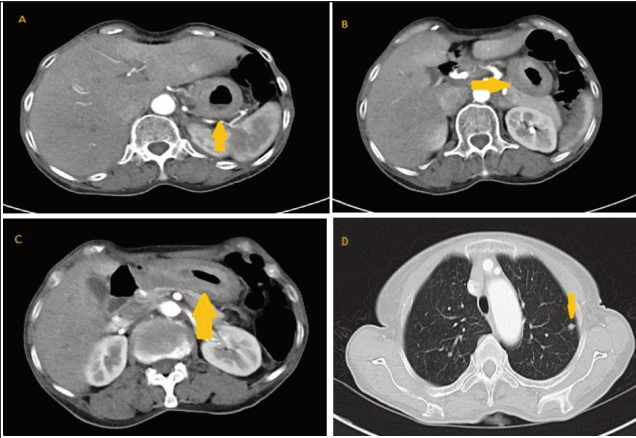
(A, B, C) Arterial phase CT abdomen showing gastric wall thickening (arrow). (D) CT chest showing metastatic pulmonary nodule (arrow).
